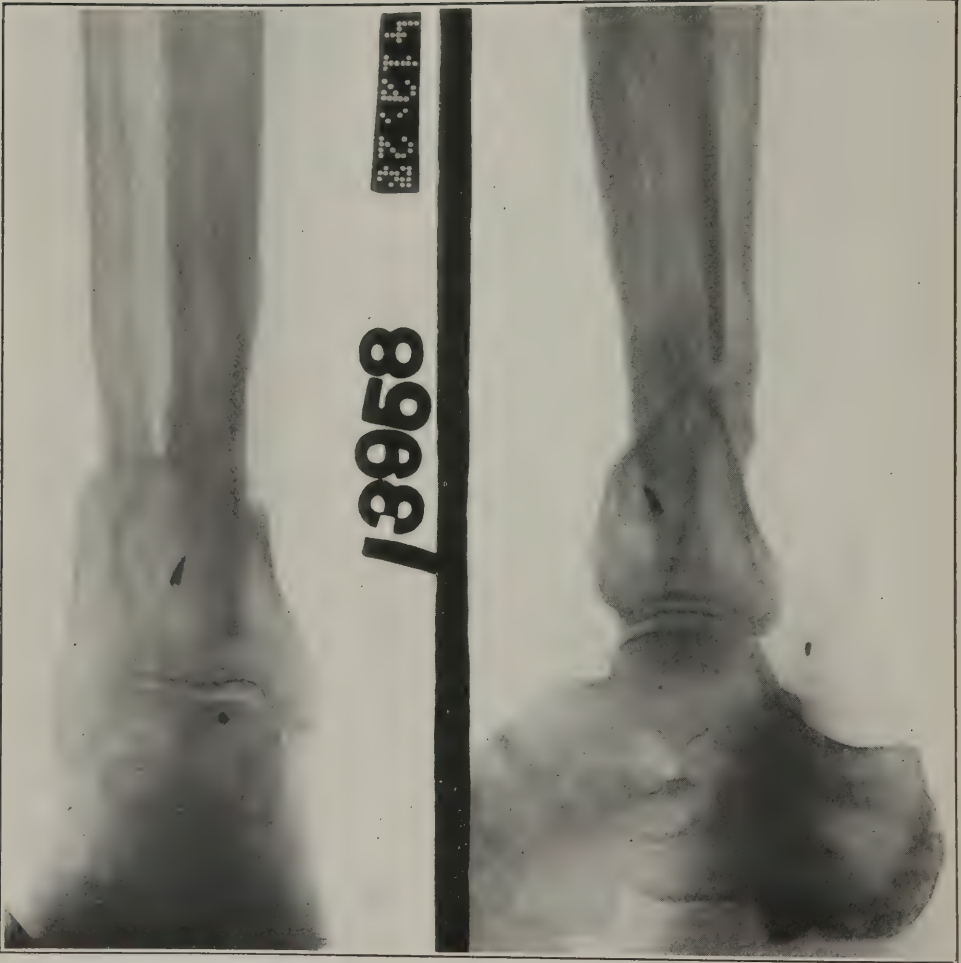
Case 15. Roentgenogram 11 months after graft. Outline of graft can barely be distinguished. Note union in fibula
